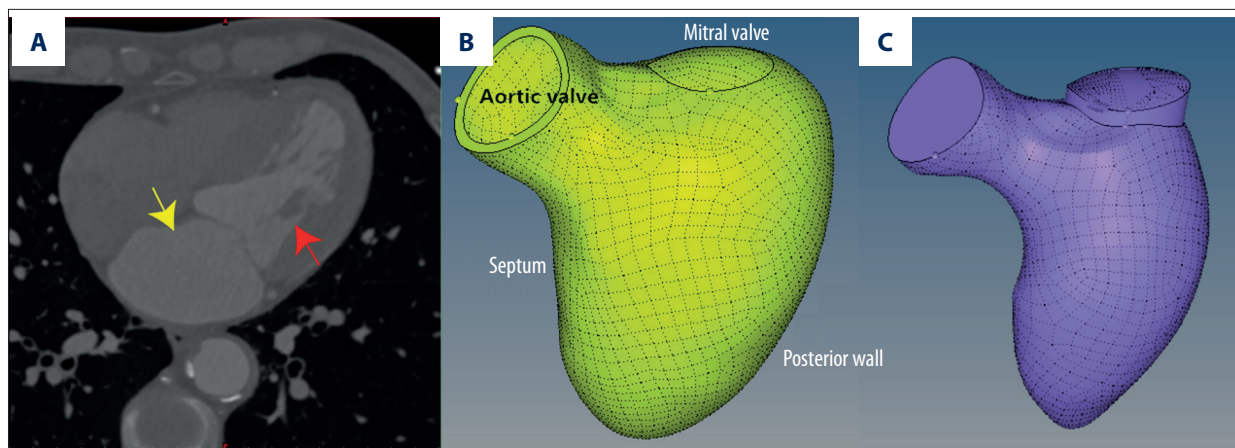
The geometric model of the left ventricle. (A) Is the CT scan data of the left ventricle, including left ventricle (red arrow) and left atrium (yellow arrow); (B) Is the structure model of the left ventricle; (C) Is the fluid model of the blood in the left ventricle.
